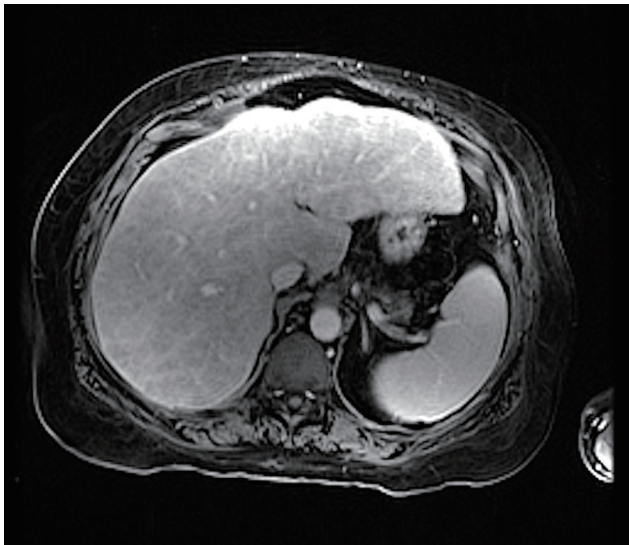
Contrast-enhanced arterial phase MRI of the liver demonstrating moderate heterogeneity (score of 3). MRI, magnetic resonance imaging.
